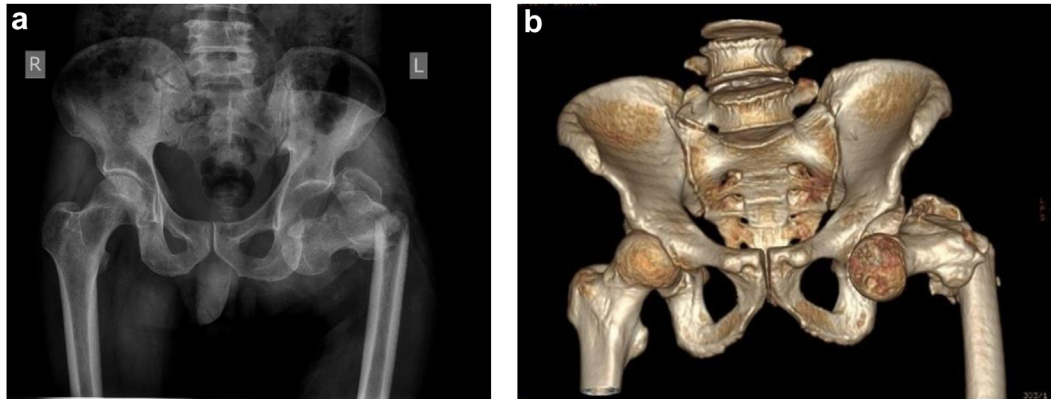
Radiological investigations showing femoral fracture with anterior hip dislocation. (a) Preoperative anteroposterior radiograph of pelvis. (b) Preoperative anteroposterior CT pelvis with 3D reformat.
